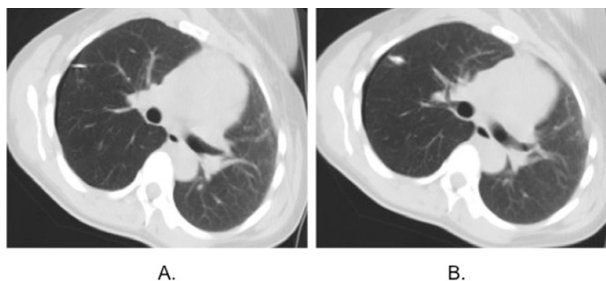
CT chest/thorax of before (A) and after (B) injection with methylene blue to localize a right upper lung nodule.
